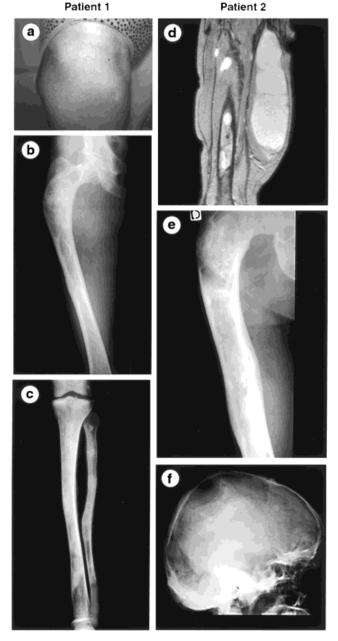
a: Right thigh of Patient 1. Note the large café-au-lait spots with irregular edges. b,c: Radiographs of Patient 1. Multiple radiolucent areas throughout the femur and a "ground glass" appearance typical of fibrous dysplasia. The tibia and fibula show bowing throughout the whole length of the diaphysis. d: Coronal T_2 -weighted MR image of Patient 2, demonstrating a large hyperintense well-defined mass of the right thigh. e,f: X-rays of Patient 2. Note the radiolucent areas of the vertex and the parietal bones, the occipital thickening and the irregularity of the skull. The femora is irregular, with areas of osseous remodeling with large cloudy zones of osteolysis and patchy sclerosis. Note the deformity of the upper femur.
